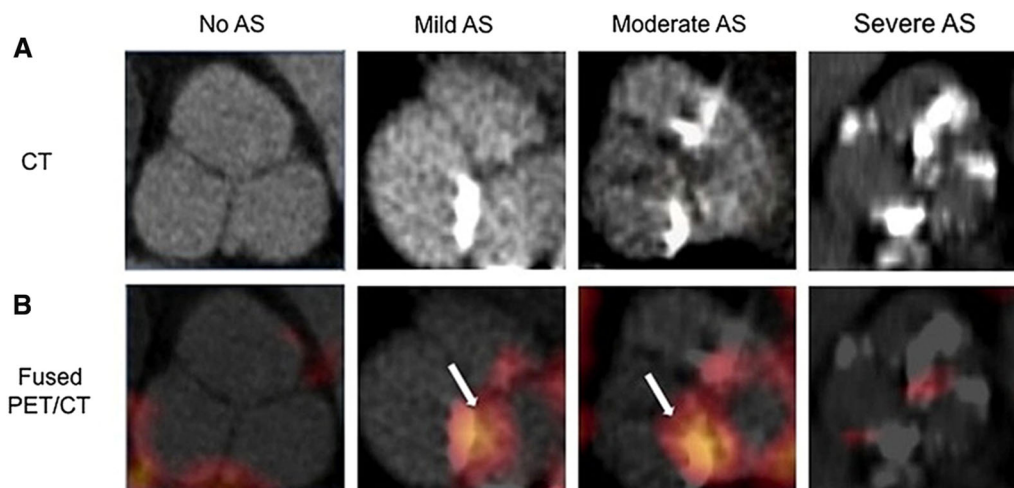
^{18}F -FDG imaging of CAVD. Examples of CT images (A) and fused ^{18}F -FDG-PET/CT images (B) of aortic valve in patients with different stages of CAVD. Arrows point to ^{18}F -FDG uptake in aortic valve. AS, Aortic stenosis. Adapted with permission from Elsevier and Copyright Clearance Center, Journal of the American College of Cardiology,³⁴ © 2011.
